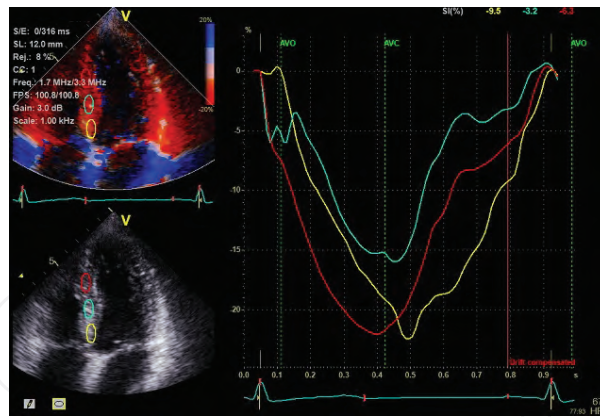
Strain analysis from tissue Doppler imaging from three representative regions of interest (ROIs) in LV septal wall.
